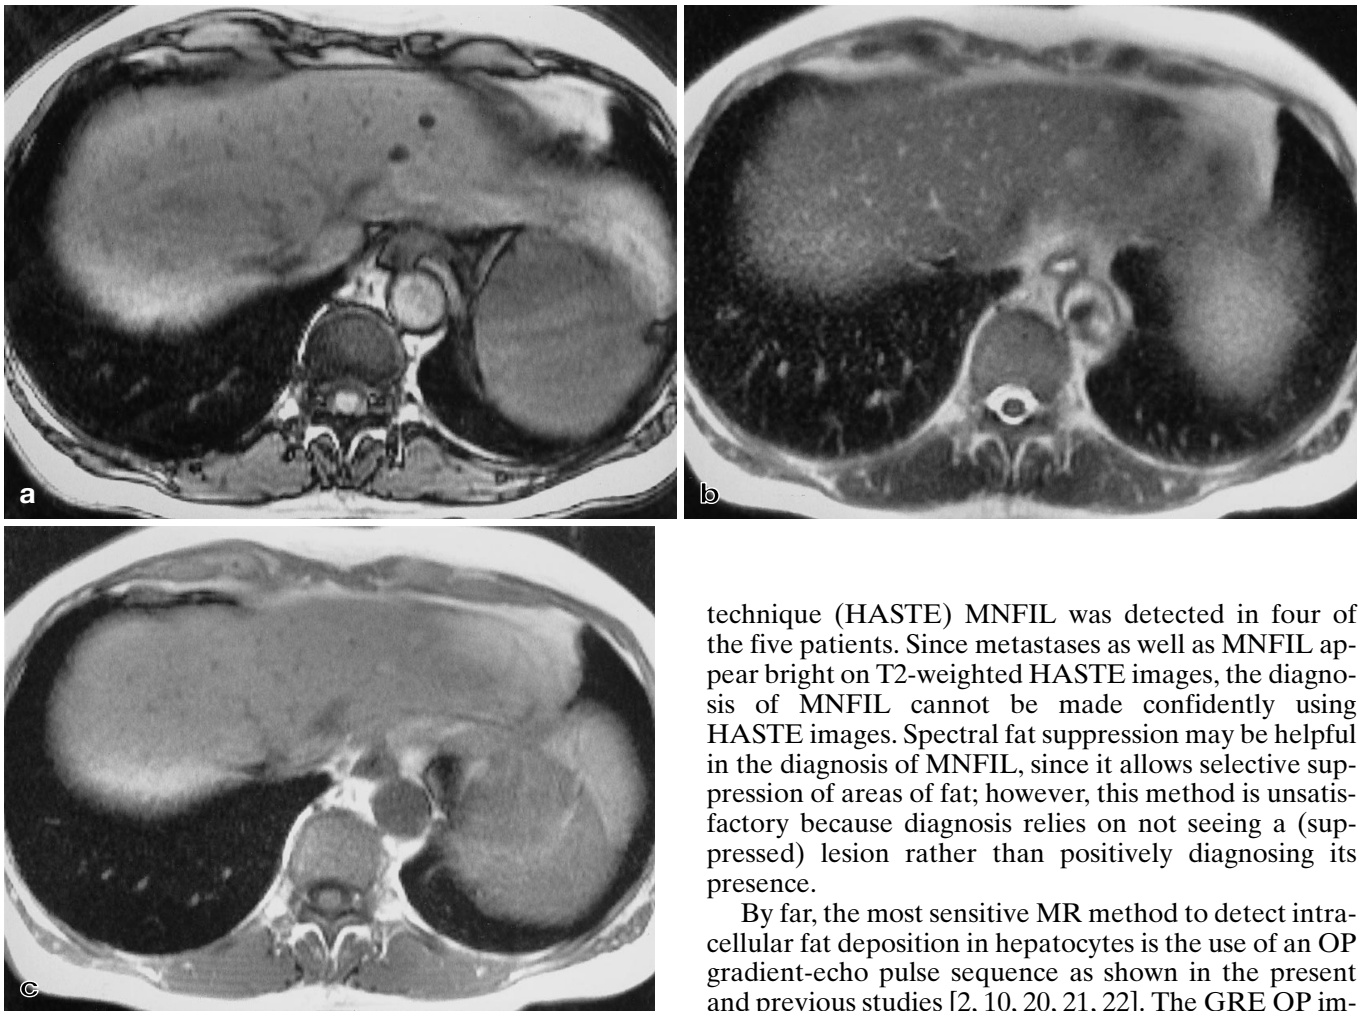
a–c. Magnetic resonance images of a 77-year-old patient with breast cancer and suspected liver metastases on CT (not shown). a On T1-weighted GRE opposed-phase images two sharply demarcated focal liver lesions are seen in the left lobe of the liver, which show homogeneously low signal intensity compared with surrounding liver parenchyma. b On T2-weighted HASTE images and on c T1-weighted GRE in-phase images the two lesions are slightly hyperintense. Comparison of T1-weighted GRE in-phase and opposed-phase images confirms the diagnosis of MNFIL and rules out malignancy
